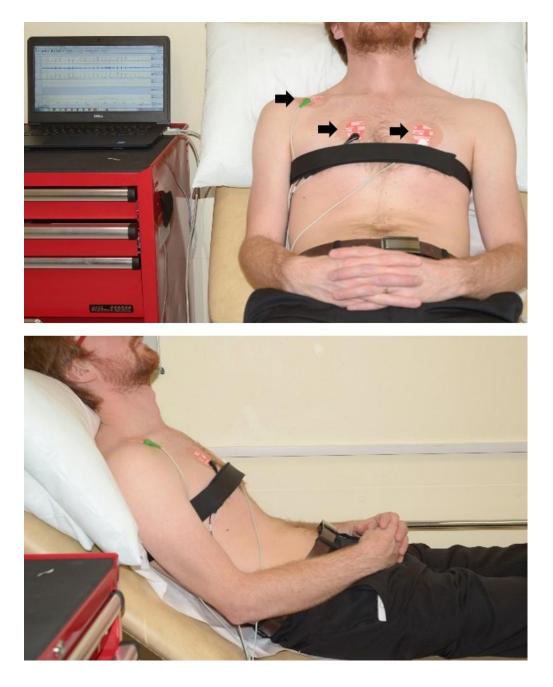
Patient position for parasternal electromyogram recording: Patient positioned at 45 degrees with parasternal electrodes placed in the 2nd intercostal space and right clavicle (black arrows). Respiratory impedance plethysmography (RIP) band is wrapped around the patient's thorax.
